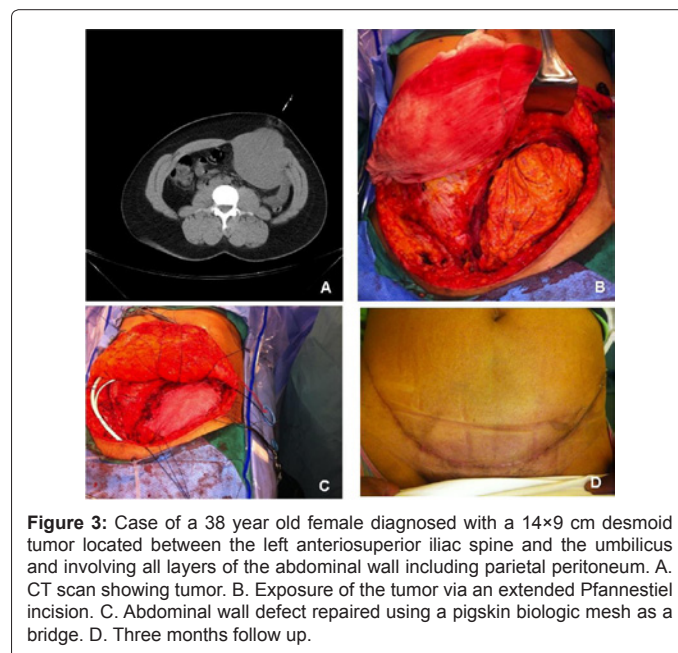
Case of a 38 year old female diagnosed with a 14x9 cm desmoid tumor located between the left anterosuperior iliac spine and the umbilicus and involving all layers of the abdominal wall including parietal peritoneum. A. CT scan showing tumor. B. Exposure of the tumor via an extended Pfannenstiel incision. C. Abdominal wall defect repaired using a pigskin biologic mesh as a bridge. D. Three months follow up.
